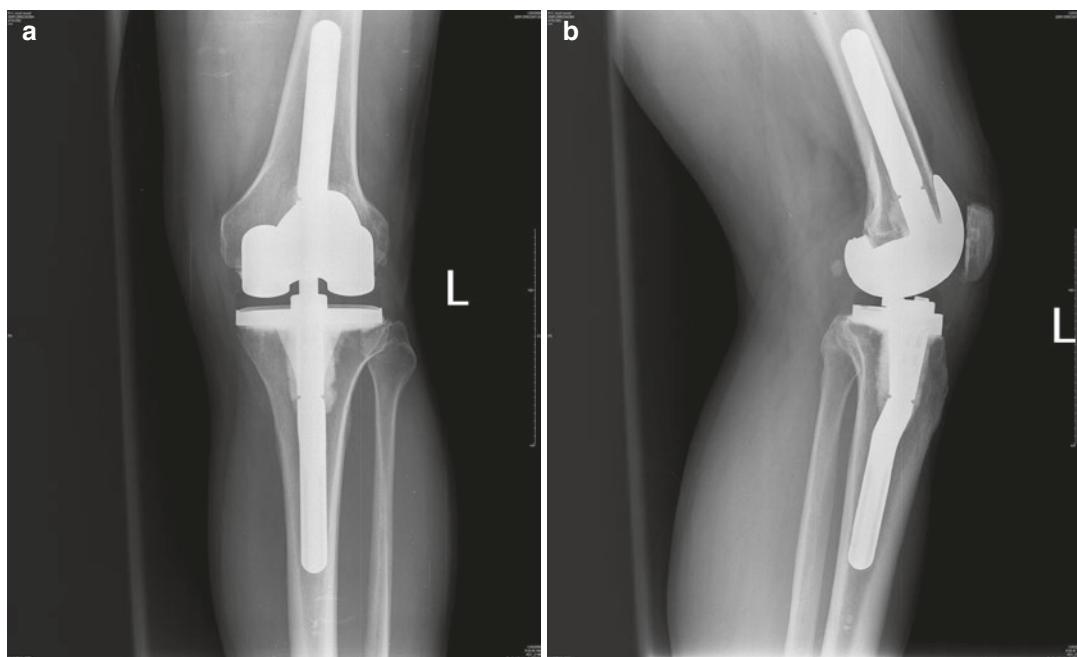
Anteroposterior (AP) (a) and lateral (b) radiographs after a revision arthroplasty. The femoral component was upsized, and posterior augments were used. Note the restoration of the posterior femoral condylar offset
